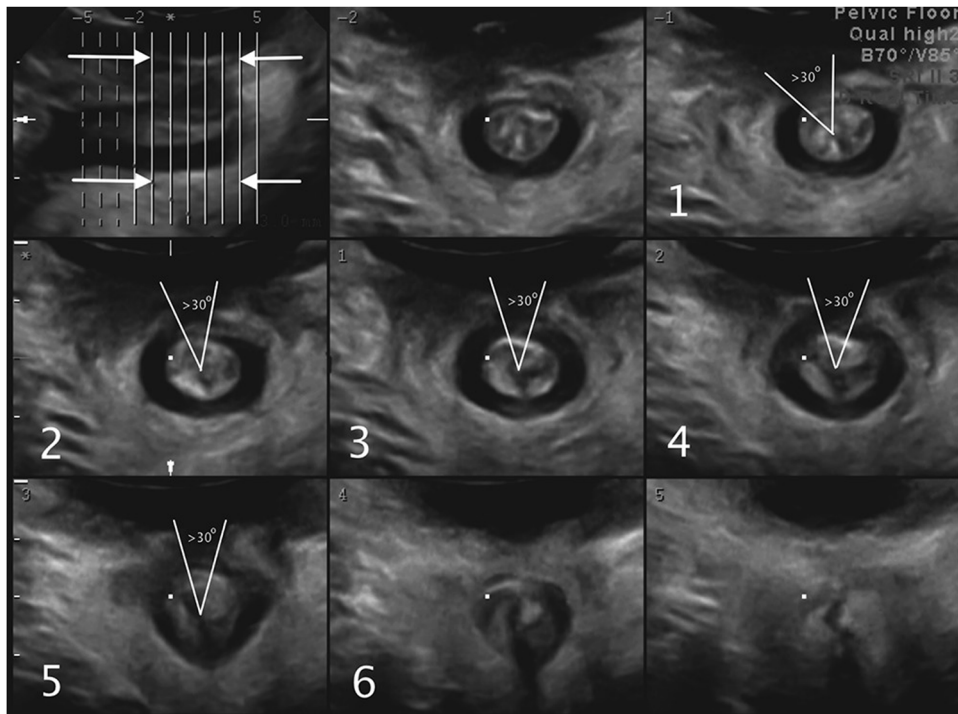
Assessment of the integrity of the anal sphincter complex assessed with tomographic ultrasound imaging plane (reproduced with permission from Guzman Rojas et al.¹³³)
